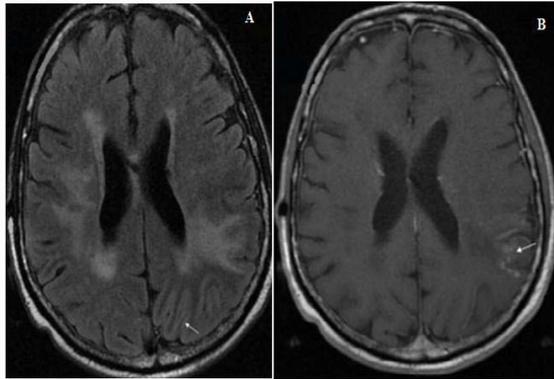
Brain magnetic resonance imaging A). Axial FLAIR T2-weighted sequence reveals left temporal gyriform cortical hyperintensity (arrow). B). Axial T1 weighted sequence with gadolinium shows leptomeningeal enhancement after gadolinium contrast (arrow).
